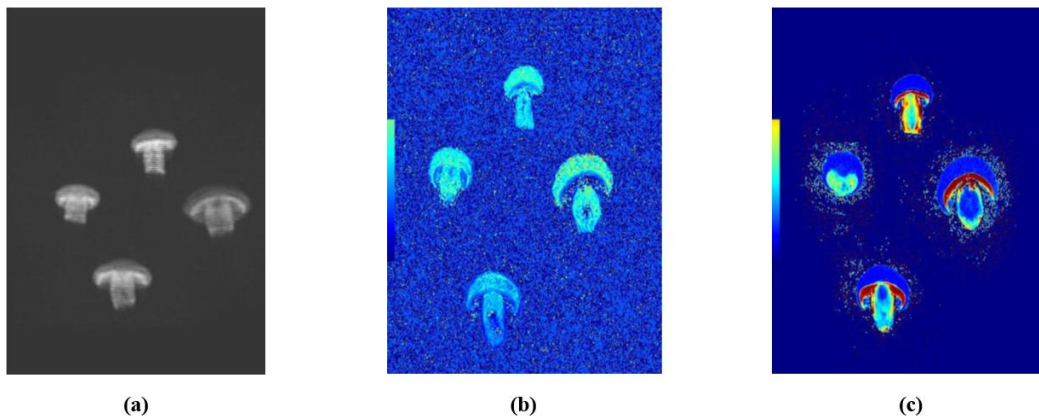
MRI Scan of mushrooms coated with Gelatin. (a) T₁ MPRAGE; (b) T₁ MAP; (c) T₂ MAP. T₁ MAP gives lipid profile and T₂ MAP gives water profile of mushrooms.
